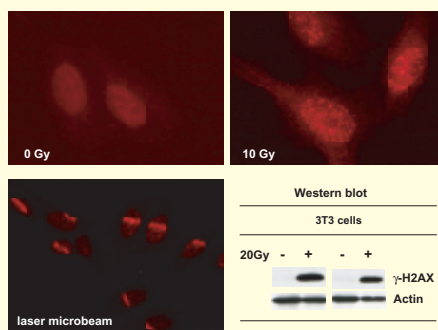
Detection of DNA damage induced globally (X-ray irradiation with 10 Gray) or locally (laser microbeam irradiation) with anti- γ -H2AX PAB (Prod. No. ALX-210-390). Picture courtesy of C. Spenlehauer & G. de Murcia (CNRS, Strasbourg).
